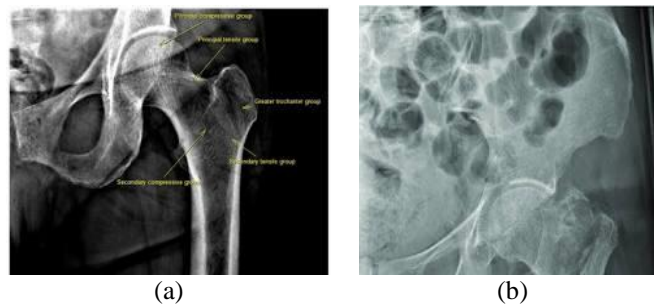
(a) This femoral neck X-ray displays normal bone density and trabecular structure, with a smooth cortical outline and no signs of fractures, (b) This femoral neck X-ray reveals significant osteoporosis, characterized by reduced bone density, thinning of the cortex, and a loss of trabecular structure.
